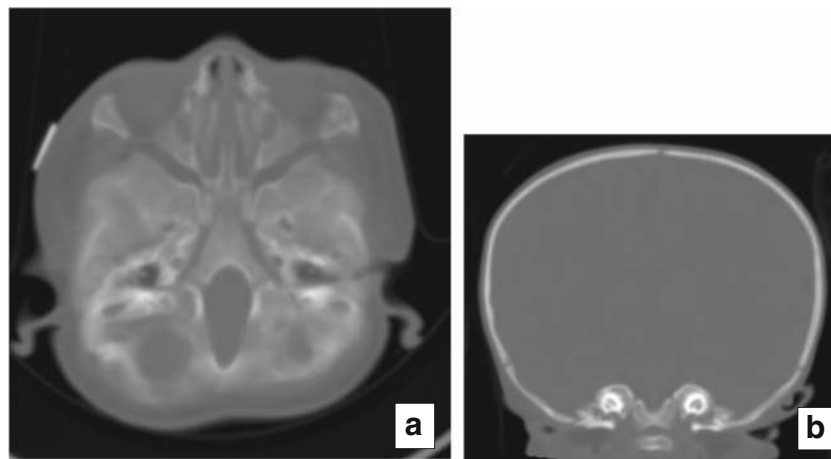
Left is an axial MRI image at the level of the foramen magnum. Note the narrow and distorted shape of the foramen. In b which is a coronal image through the base of the skull showing elevation of the structures adjacent to the foramen due to distortion of the normal position of these structures as a result of pressures on the softened bone
